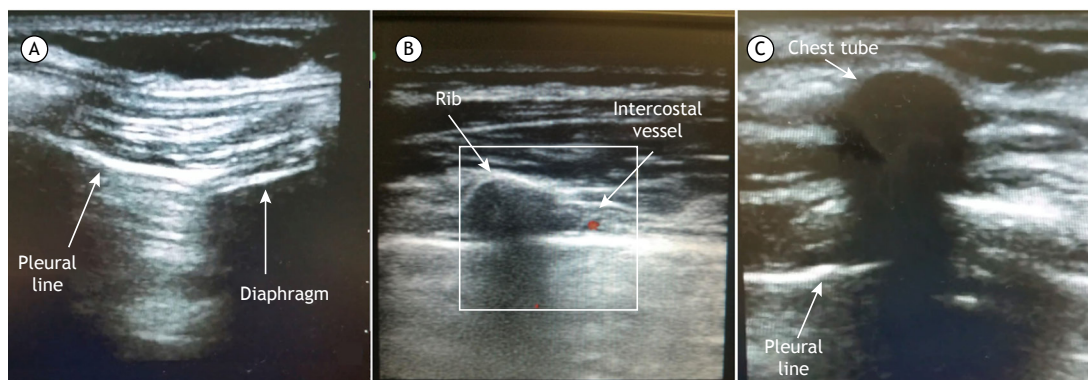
Tube thoracostomy. a) Brightness (B)-mode image, obtained with a linear probe, showing diaphragmatic excursion and a normal lung. The examiner evaluates the range of diaphragmatic excursion during a full cycle of ventilation. This enables the examiner to choose the lowest site for tube insertion while avoiding injury to the diaphragm. If the previously selected site exhibits diaphragmatic movement, a more cranial intercostal space must be scanned. b) Visualization of intercostal vessels using Doppler ultrasound. Once the examiner finds a suitable intercostal space, the insertion site should be scanned with Color Doppler. The intercostal artery most commonly lies on the upper third of the intercostal space. The entire intercostal space should be scanned in order to make sure that there is no blood flow along the insertion path. c) Confirmation of correct positioning of the drain. Axial view of a large-bore chest tube, showing the characteristic hyperechoic arc over a black circle with posterior acoustic shadowing, seen along the subcutaneous plane. Following that image along the drainage site, one should see the drain deepening toward the pleural line.
